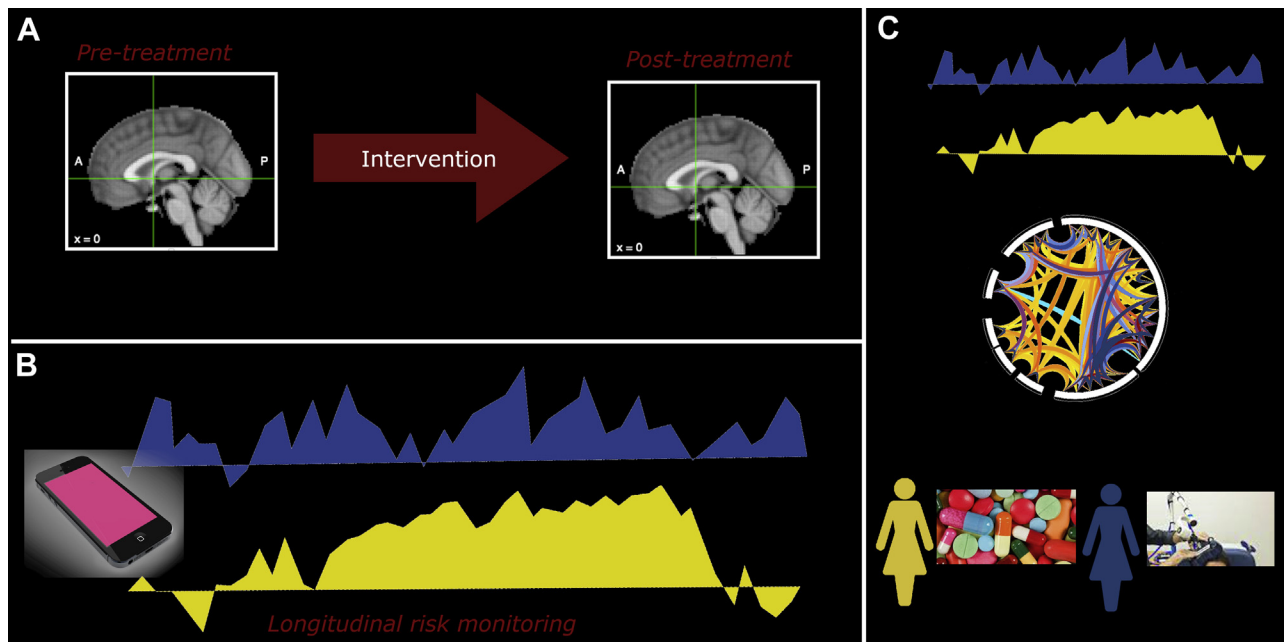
Incorporating longitudinal methods into suicide intervention research. Integration of methods providing insight into biological mechanisms and temporality is critical for the advancement of neuroscience-based interventions for suicide. (A) One approach is to measure participants' brain activity via neuroimaging or electrophysiological methods before and following the administration of intervention procedures (B) while concurrently and/or subsequently monitoring risk with devices providing real-time information (e.g., actigraphy, smartphone applications). More intensive designs may include collection of serial mechanistic data from multiple time points across the course of the intervention and follow-up period, especially during high-risk periods such as the 2 weeks immediately after an inpatient hospitalization. (C) Mapping temporal phenotypes derived from digital phenotyping to neuroimaging is one approach toward bridging magnetic resonance imaging's temporal limitations. Matching treatment outcomes to digital phenotypes and biotypes can advance efforts toward personalized medicine approaches to suicide prevention and intervention; for example, phenotypic data could inform the selection of treatments or implementation parameters (e.g., functional magnetic resonance imaging to guide which circuits are targeted via transcranial magnetic stimulation). A, anterior; P, posterior.
